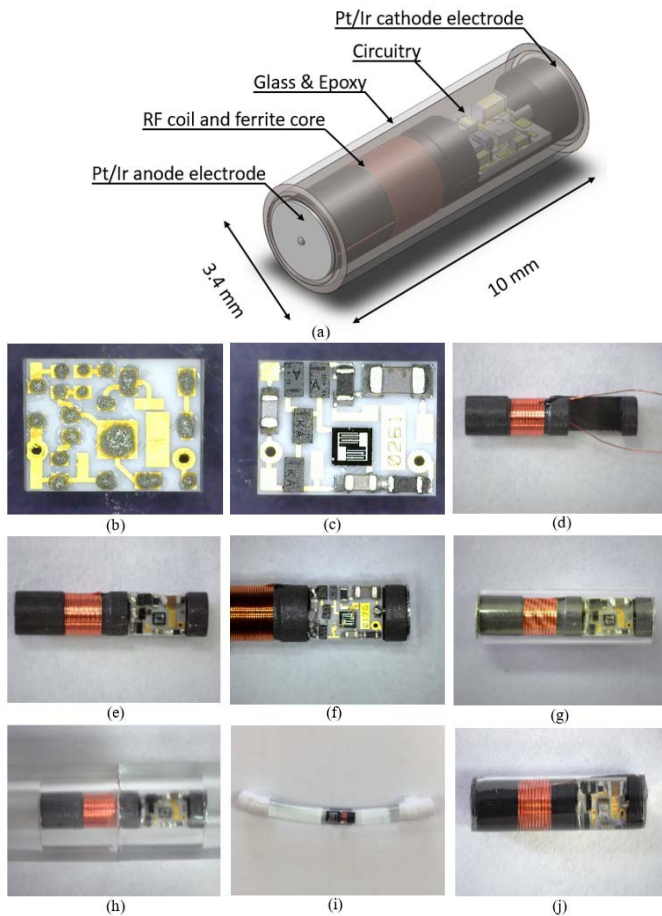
a.* Design of NuStim implant. *b-j.* Construction steps. *b.* Lead free solder paste is applied on the PCB. *c.* The surface-mount components are placed and soldered on hot plate (240°C for 30s). *d.* Ferrite is wound with insulated copper wire and cleaned in ultrasound. *e.* PCB is mounted on the ferrite with epoxy. *f.* coil terminals and electrodes are soldered. Wirebonds are placed to connect the PUT. *g.* Device is inserted and tacked inside the glass capillary. *h.* Device is loaded inside silicone tubes and filled with epoxy. *i.* Epoxy is cured. *j.* Extra epoxy is trimmed off and the device is ready for functional testing.
